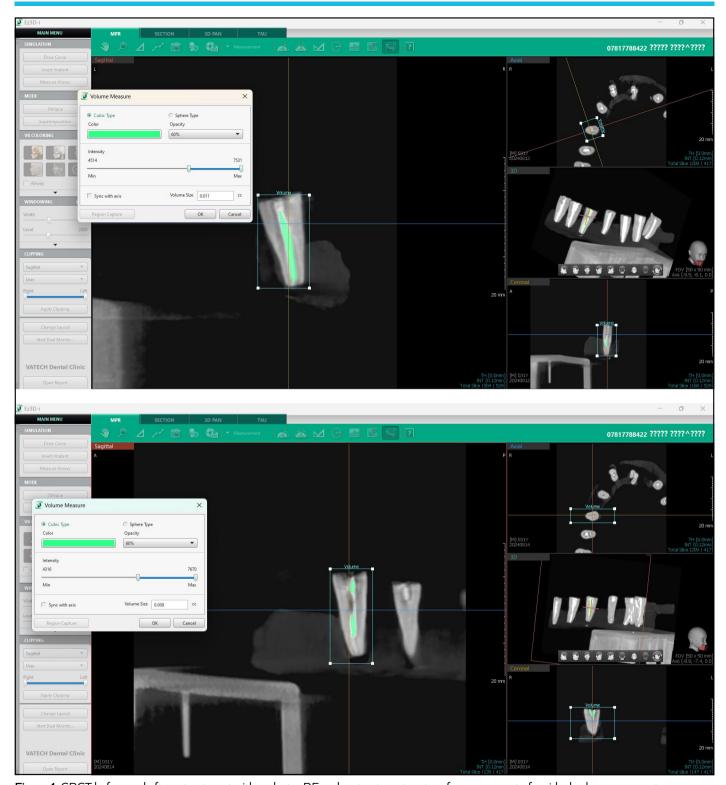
CBCT before and after retreatment with endostar RE endo retreatment system for assessment of residual volume remanent. CBCT: Cone-beam computed tomography.
